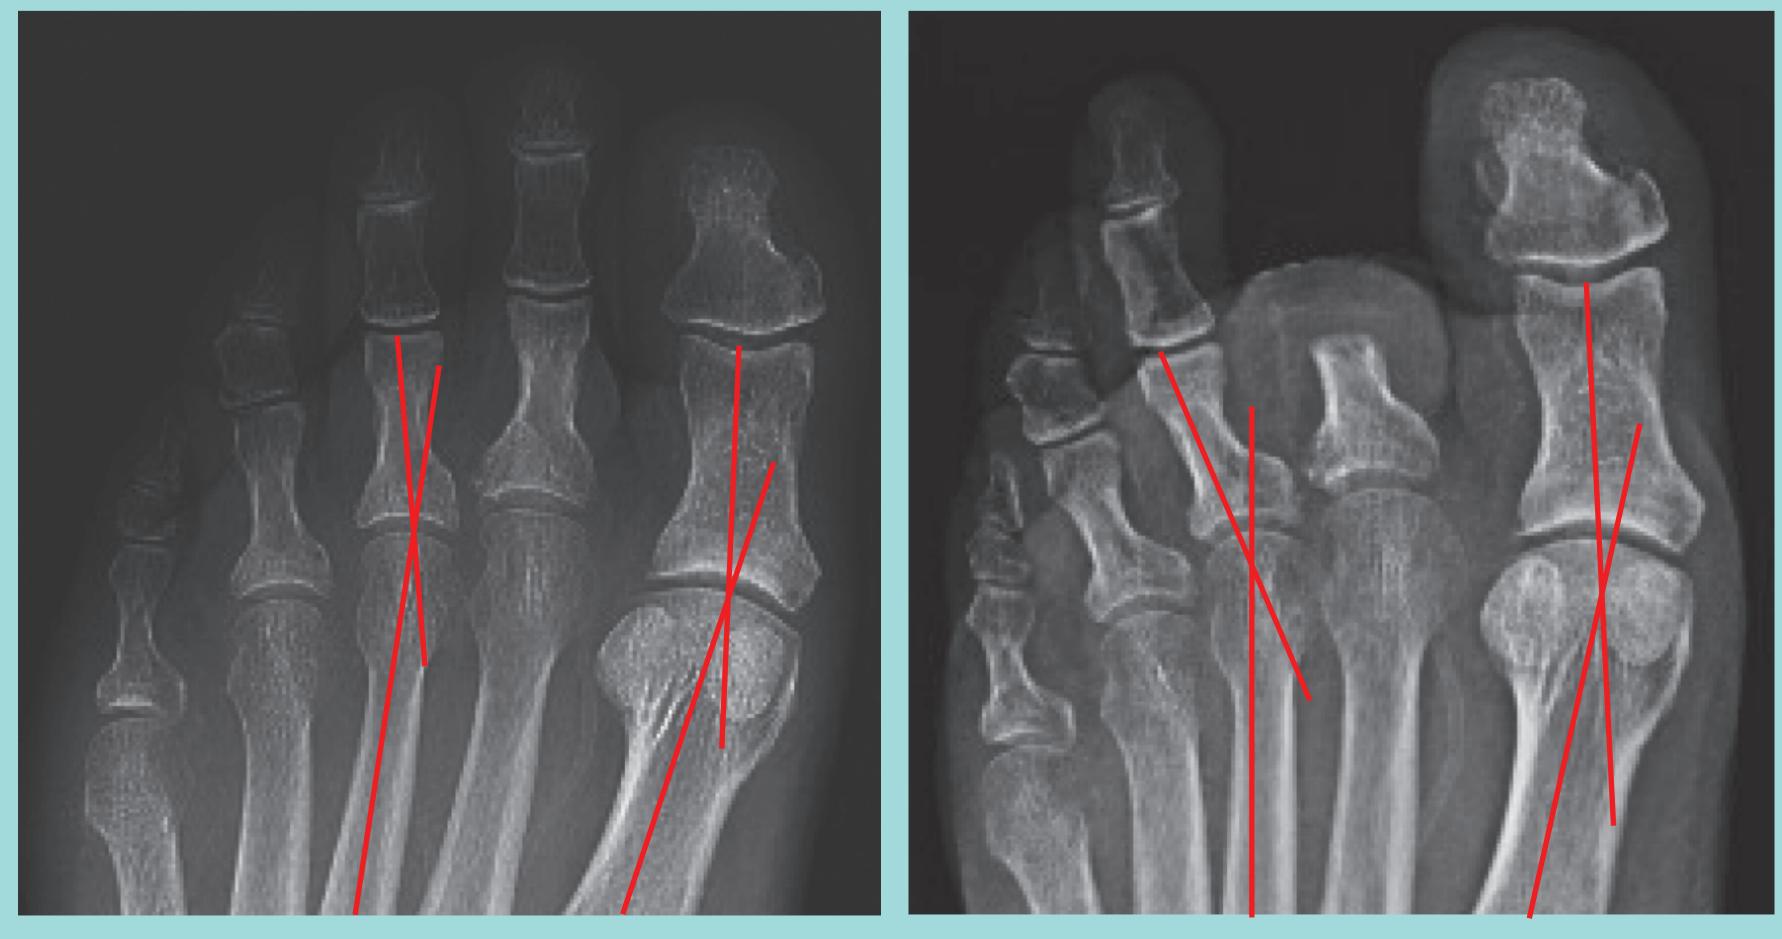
Example Pre and Postoperative Radiographs with HAA and TPA angle.
